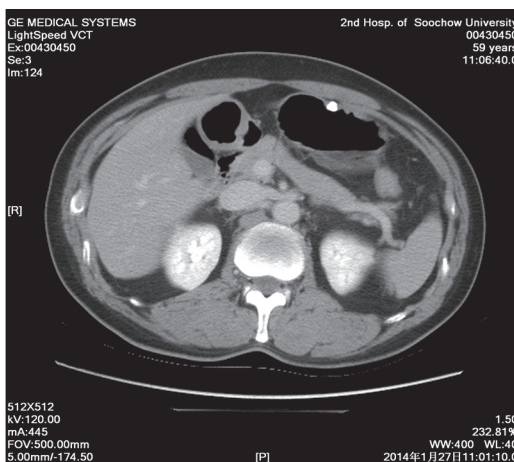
Computed tomography revealed the presence of a quasi-circular dense shadow originating from the gastric wall, indicating the presence of a calcification
